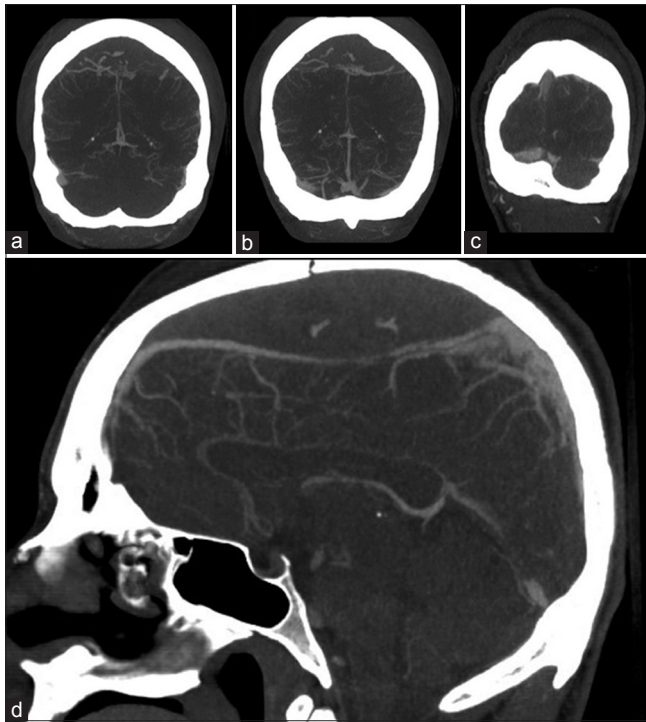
Preoperative CT angiogram head – (a-c) coronal cuts, progressively more posterior, showing downward displacement of the superior sagittal sinus (SSS) with spot signs within the epidural hematoma suggestive of active extravasation. (d) mid-sagittal cut, showing attenuation of the SSS in the posterior frontal region suggesting possible sinus injury or compression
